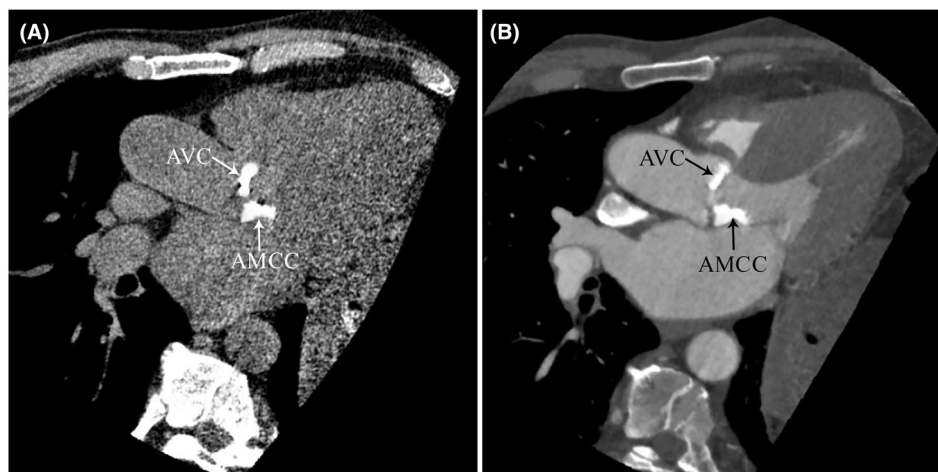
Example of severe aortomitral continuity calcification (AMCC) on computed tomography (CT). A 79-year-old male patient with conduction disturbance. Noncontrast (A) and contrast-enhanced (B) CT images of the left ventricular outflow tract show aortic valve calcification (AVC) and AMCC. The AMCC score was calculated as 268 using the Agatston score method and 234 mm^3 using the volume score method.
